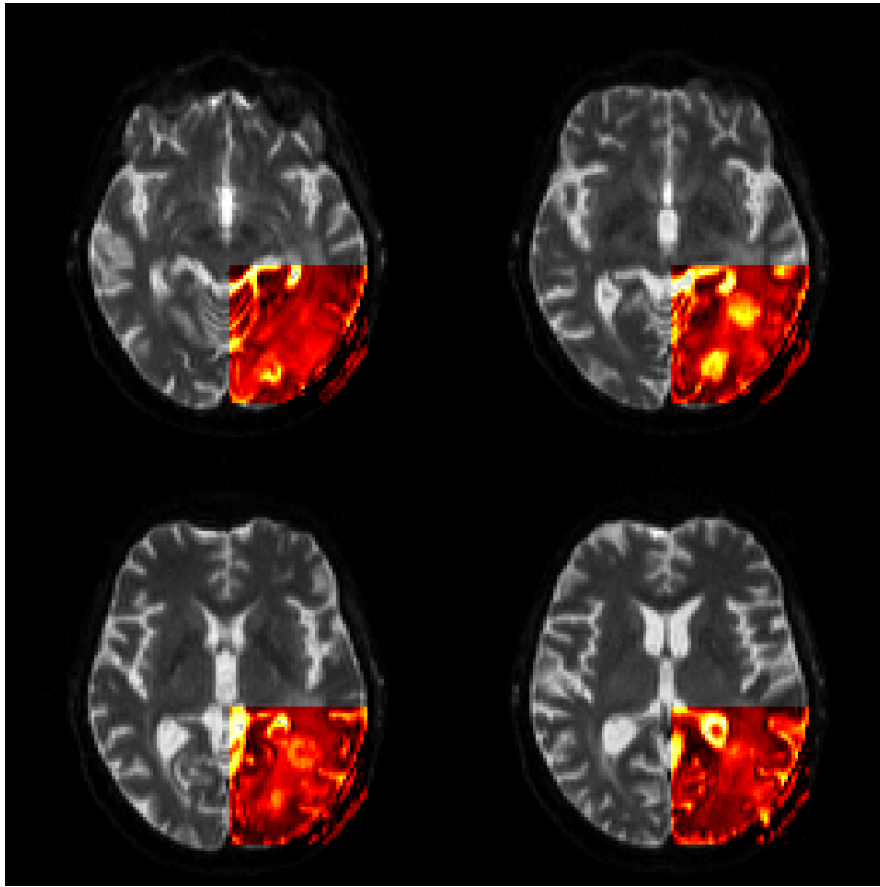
Statistical images of the apparent diffusion coefficient (ADC) values for the RIDER Neuro MRI data. The range of displayed values of the ADC is $[0.0005, 0.003] \text{ mm}^2/\text{s}$.
